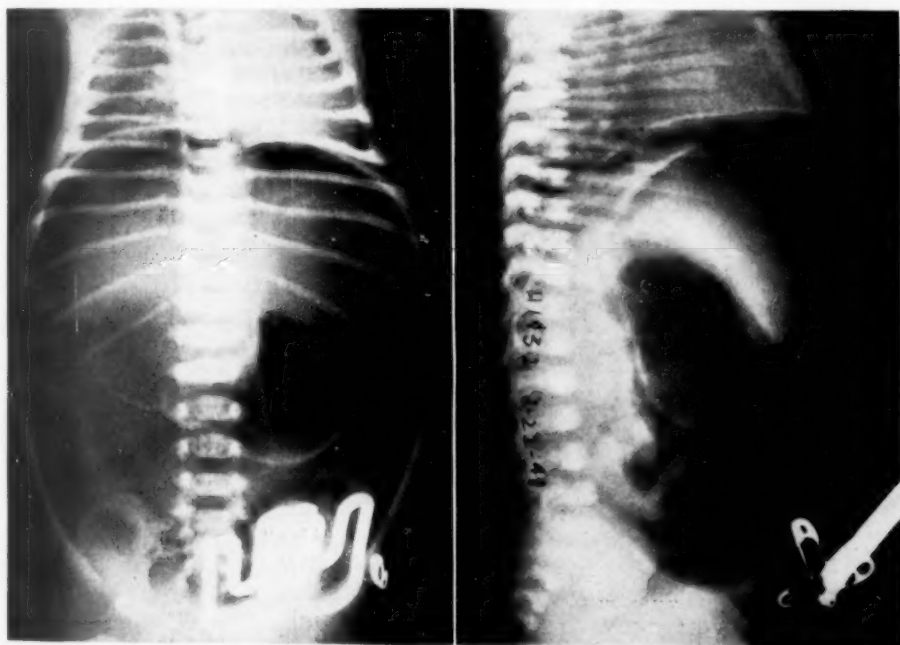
Case 3. Atresia of duodenum proximal to the ampulla with perforation and pneumoperitoneum. The roentgenograms show the distended stomach and duodenum as though suspended in gas within the peritoneal cavity. The collapsed small and large intestines can be seen. No contrast media necessary.
